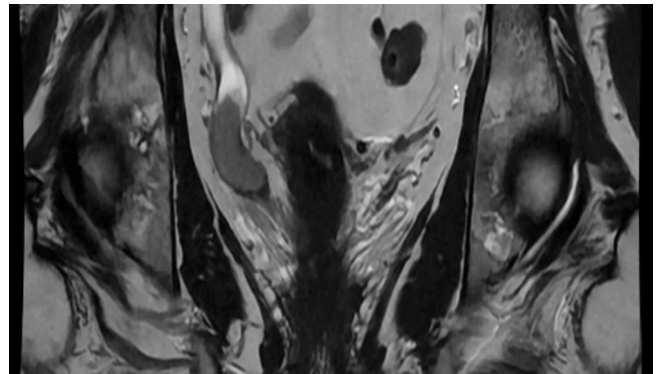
MRI image showing lesion along right distal ureter.
